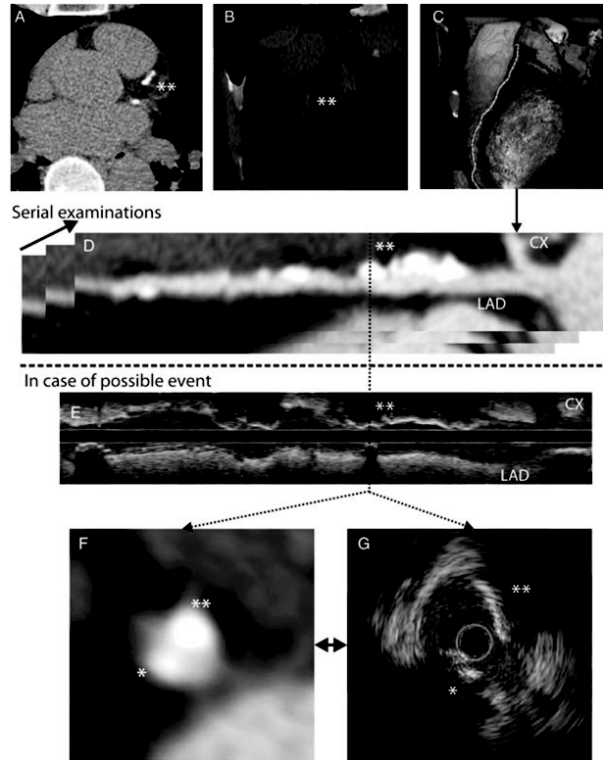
(A) A cross-sectional multislice computed tomography (MSCT) image of a calcium score scan. Due to the high attenuation of calcium in MSCT scans it can be detected easily as bright areas within the images, as indicated here by , of calcium present in the proximal left anterior descending (LAD). This is the examination set-up as described by Weijs et al.¹ (B) A three-dimensional (3D) reconstruction of this calcium score acquisition in a similar projection to the 3Dreconstruction of the contrast enhanced scan in (C). Using this contrast-enhanced scan the LAD can be extracted from the MSCT image data and a comprehensive longitudinal reconstruction of the LAD (D) can be computed. Ideally these examinations should be performed longitudinally so that serial changes of the coronary artery vessel wall morphology could be evaluated over time. In such a fashion not only could the changes in the amount of calcium be detected but also serial remodelling of lesser-advanced stages of coronary artery disease and its development can be followed. In the case where a patient in this population suffers a coronary event which needs an intervention, then an additional intracoronary imaging examination, such as presented here by applying intravascular ultrasound (IVUS) (E and F), could reveal more details of the location of the calcium and other plaque components. D and E, and F and G are matched, so there is a one-to-one link between these images. The different appearances of the calcium, bright-exaggerated areas in MSCT (D and F), and bright rims with shadowing behind in IVUS (E and G), can be appreciated.
